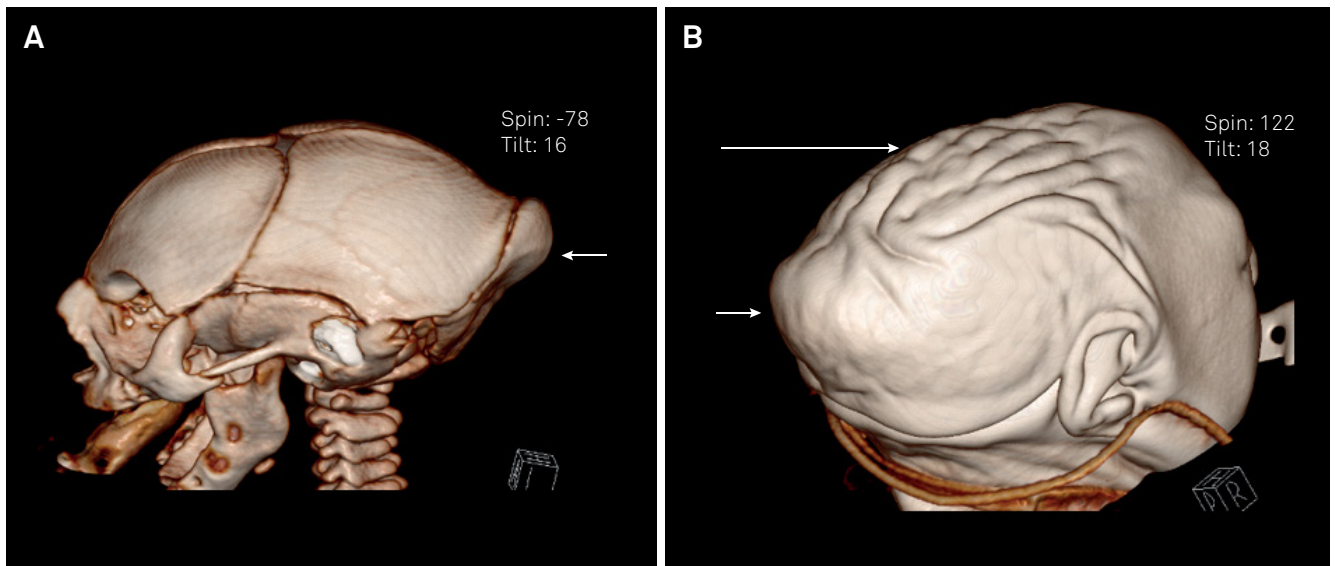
A and B show the computed tomography of the skull with reconstruction, of Patient 1, with the typical phenotype of fetal brain disruption sequence characterized by microcephaly with exuberant occipital protuberance (short arrow) and redundant skin on the scalp (long arrow).
